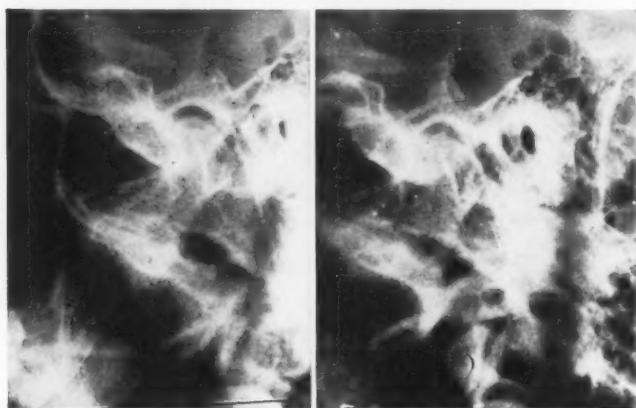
Temperomandibular X-rays, showing: (a) Position of condyle in glenoid cavity on right side with teeth closed; (b) position of condyle in glenoid cavity on right side with mandible depressed as far as possible.
